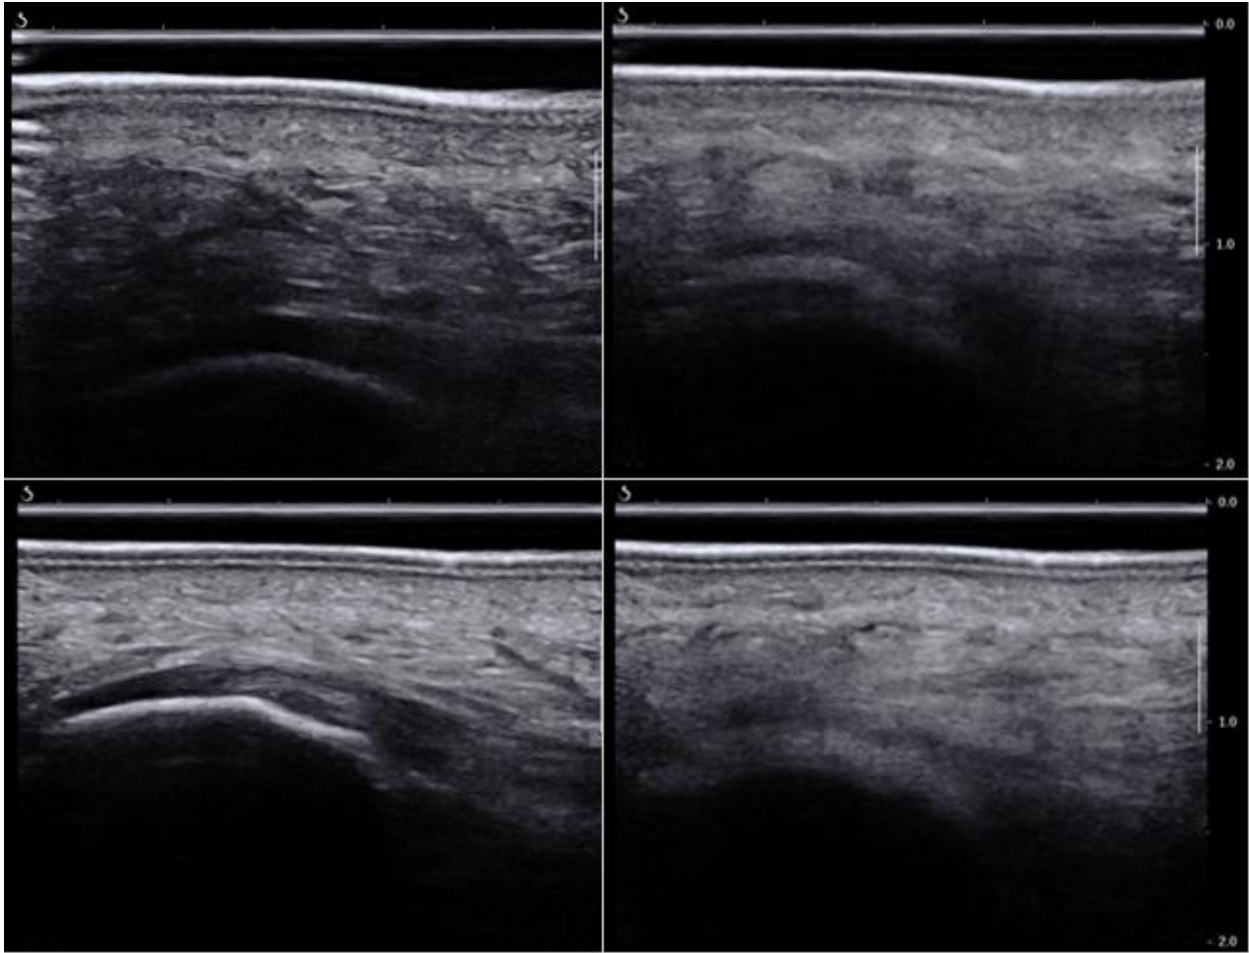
Ultrasound samples of a heel trial. Step start (top left), loading (top right), peak deformation (bottom left), and unloading (bottom right).
